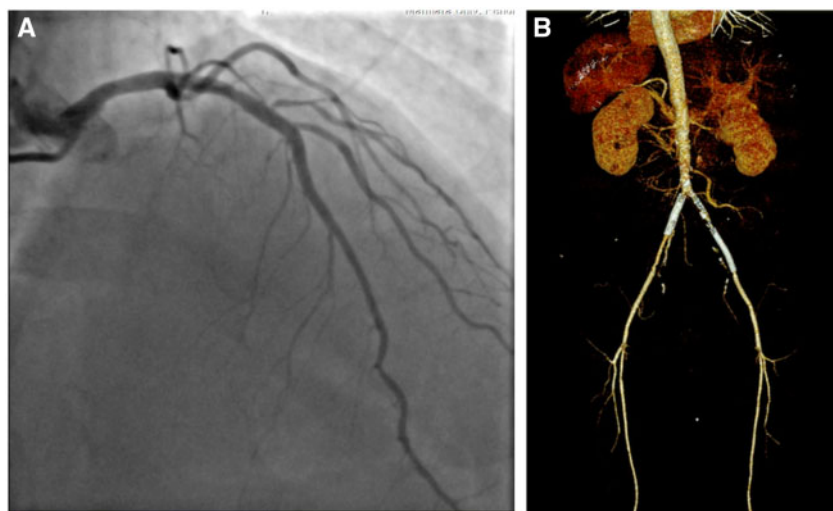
(A) Coronary angiography showed the left anterior descending, circumflex and right coronary arteries. There was non-critical coronary arterial disease and also no significant restenosis in the drug-eluting stent in the left anterior descending artery. (B) Lower extremity artery contrast enhanced computed tomography showed non-critical peripheral arterial disease.
